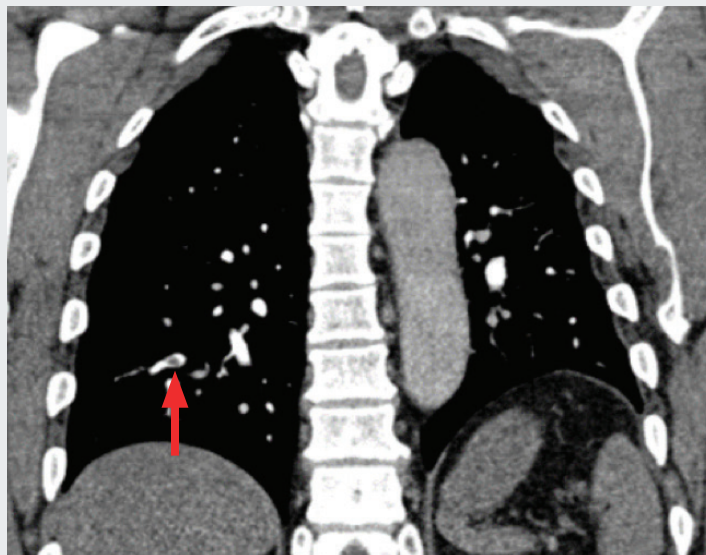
Enhanced computed tomography (coronal view) of the chest showing small filling defect in the sub segmental branches of the right lower lobe (arrow).
